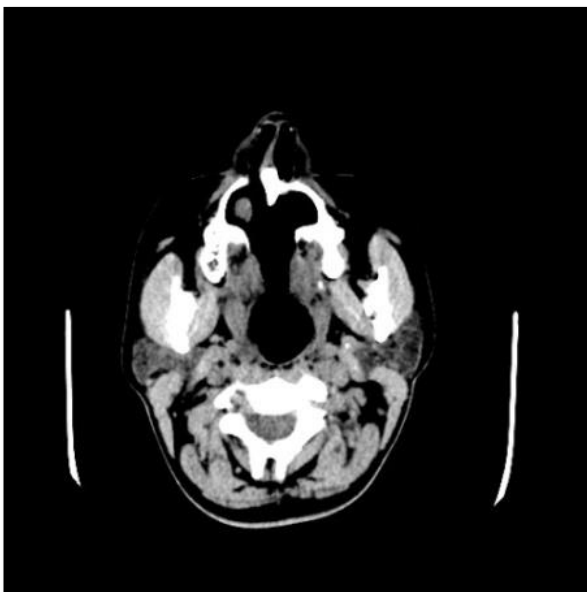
Axial Computed Tomography showing a large defect in palate extending up to uvula.
